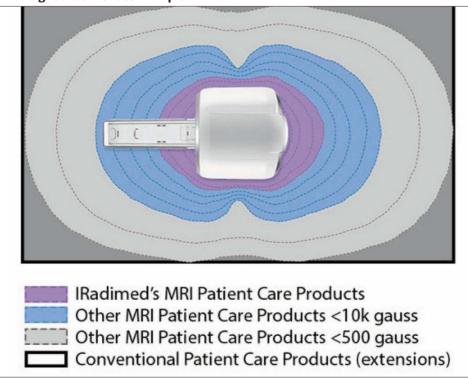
Image represents a 3 Tesla MRI system
